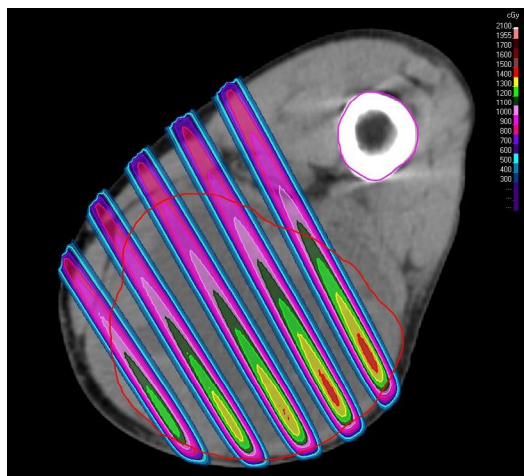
Axial CT slice of SFGRT 15 Gy dose distribution for thigh sarcoma.
